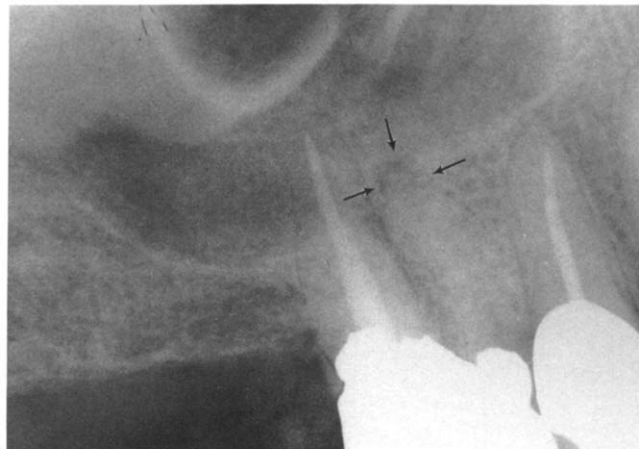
Six-month follow-up radiograph. Note the radiolucency associated with the mesiobuccal root (arrows) and the substantially reduced size of the radiolucency at the apex of the palatal root.
